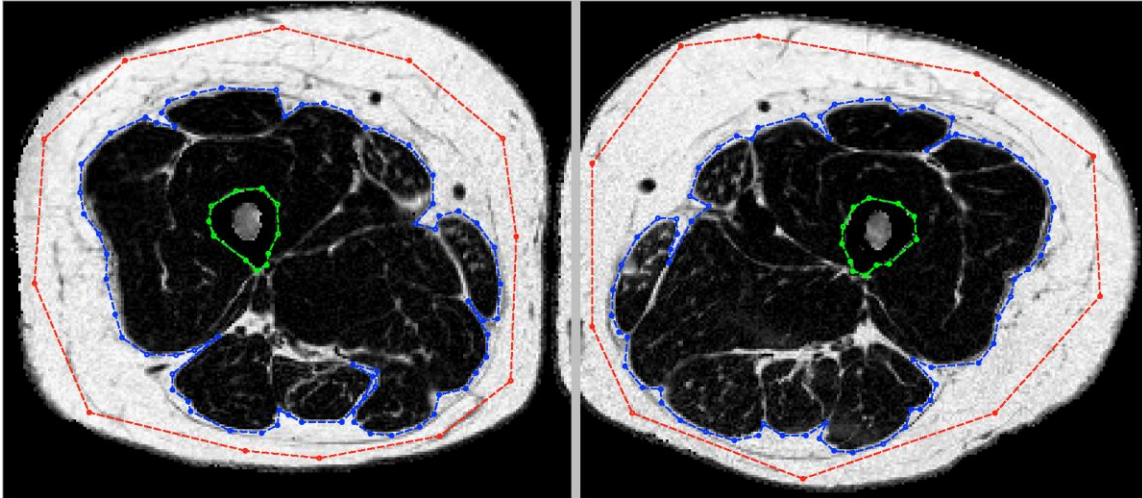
MRI of whole thigh CSA – baseline. Left side image is right thigh of IG subject. Inner dashed lines used to measure WTCSA. The dashed red line (in the middle of the white area of the scan) denotes the superficial edge of subcutaneous adipose tissue; the deeper blue dashed line represents the outer border of the thigh skeletal musculature. The area inside this blue line is the WTCSA. The dashed line near the center of the image has been drawn to indicate the border the femur.
